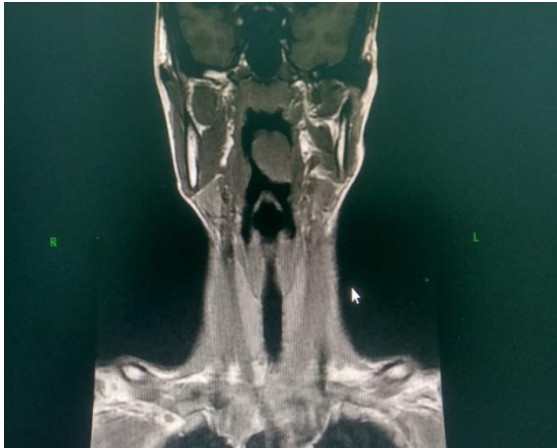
CT neck showing mass arising from left tonsillar fossa
